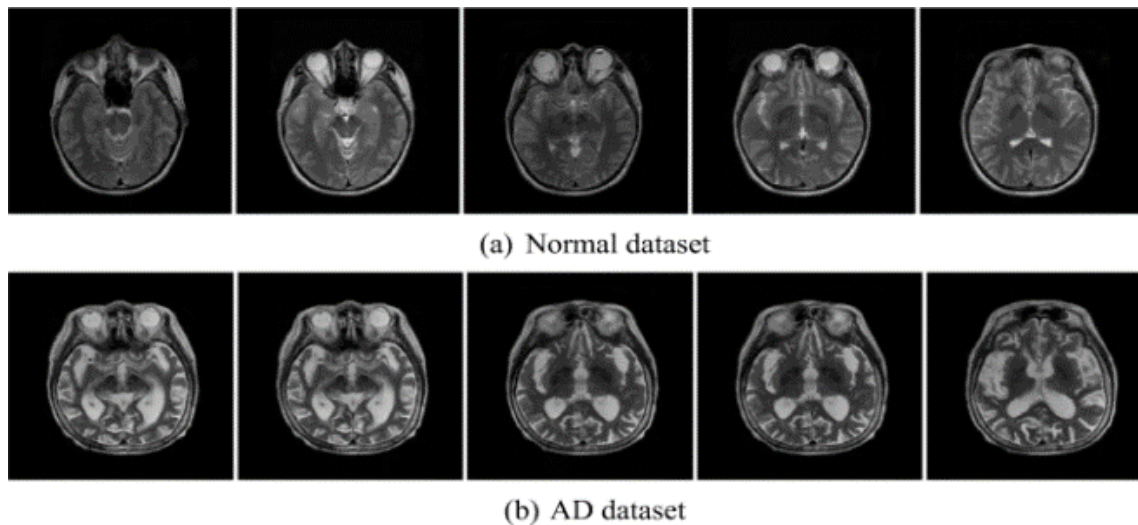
Normal Brain and AD Brain MRI Images of Dataset (Zeinab Breijyeh, et al., (2020))⁽⁵⁾
